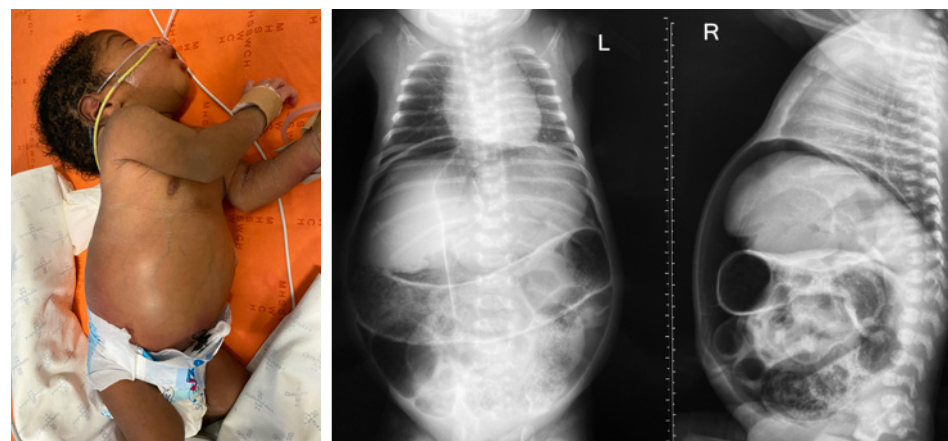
Term infant with distended abdomen and obvious pneumoperitoneum on X-ray; the ultimate diagnosis remained unknown.
